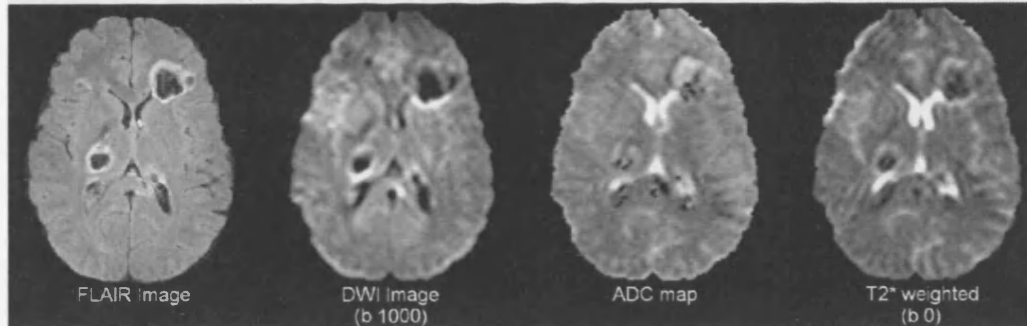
Co-registered images from left to right FLAIR, DWI ($b=1000 \text{ sec/mm}^2$ EPI acquisition), ADC map and T2* weighted image (DWI, $b=0 \text{ sec/mm}^2$ EPI acquisition)
